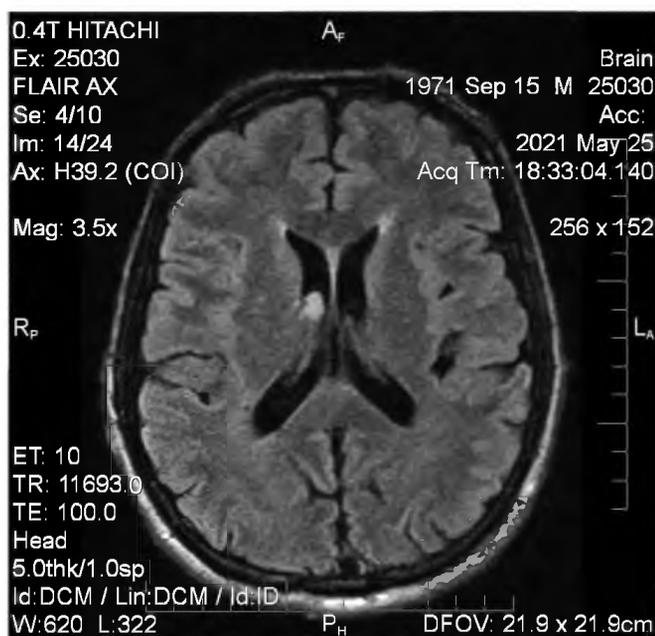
MRI of the brain of patient V. (May 25, 2021)
